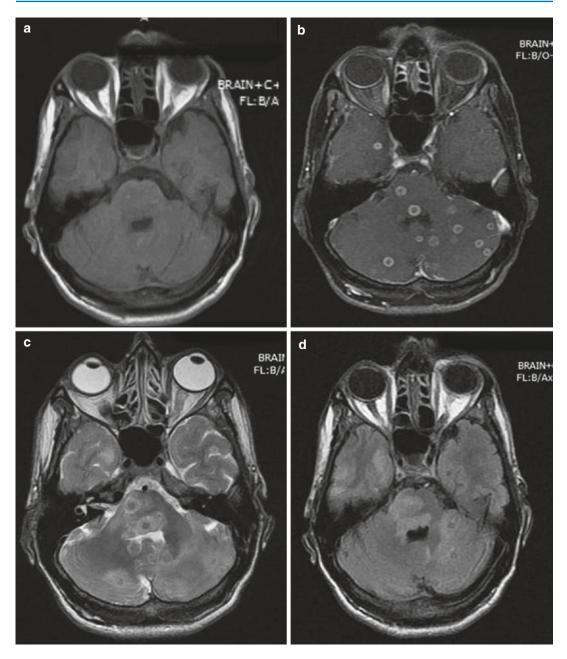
MRI of the brain showing multiple cerebellar, pontine, and right temporal hypointense lesions on T1W image (\mathbf{a}), which enhance on T1-gadolinium-contrast sequence (\mathbf{b}), in a patient with miliary TB. The lesions are
